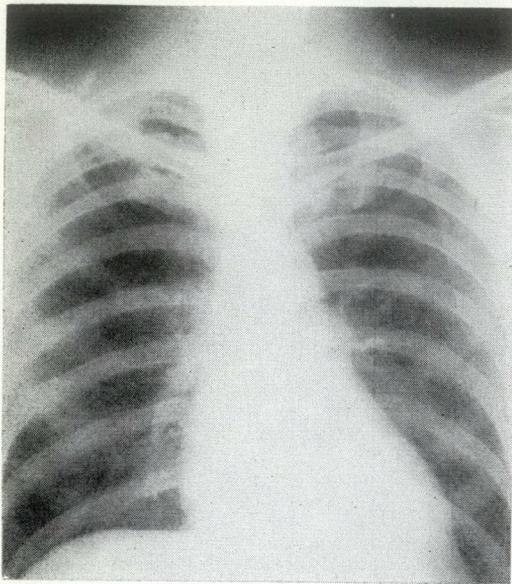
Postero-anterior radiograph of chest.
